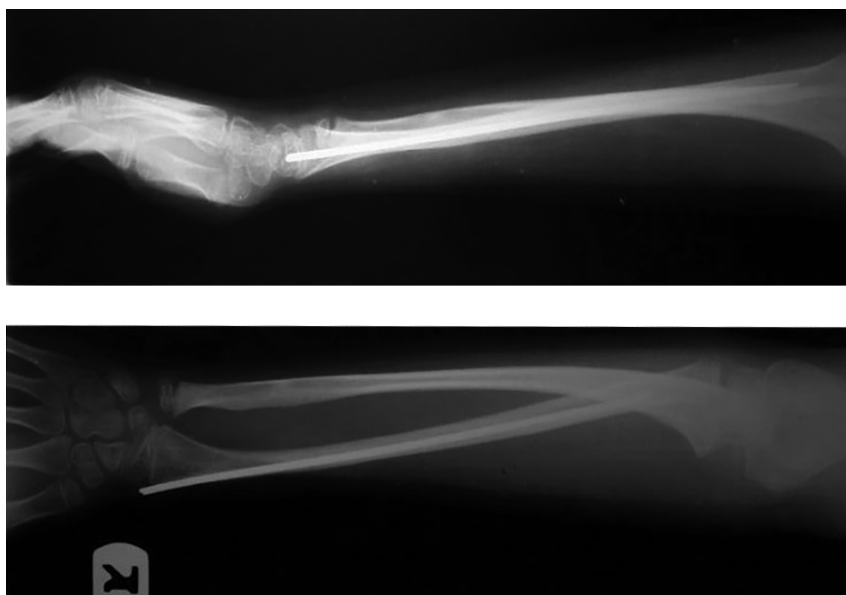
X-ray six months after fracture fixation represents the union in fracture site and longitudinal bone growth in the radius bone.
